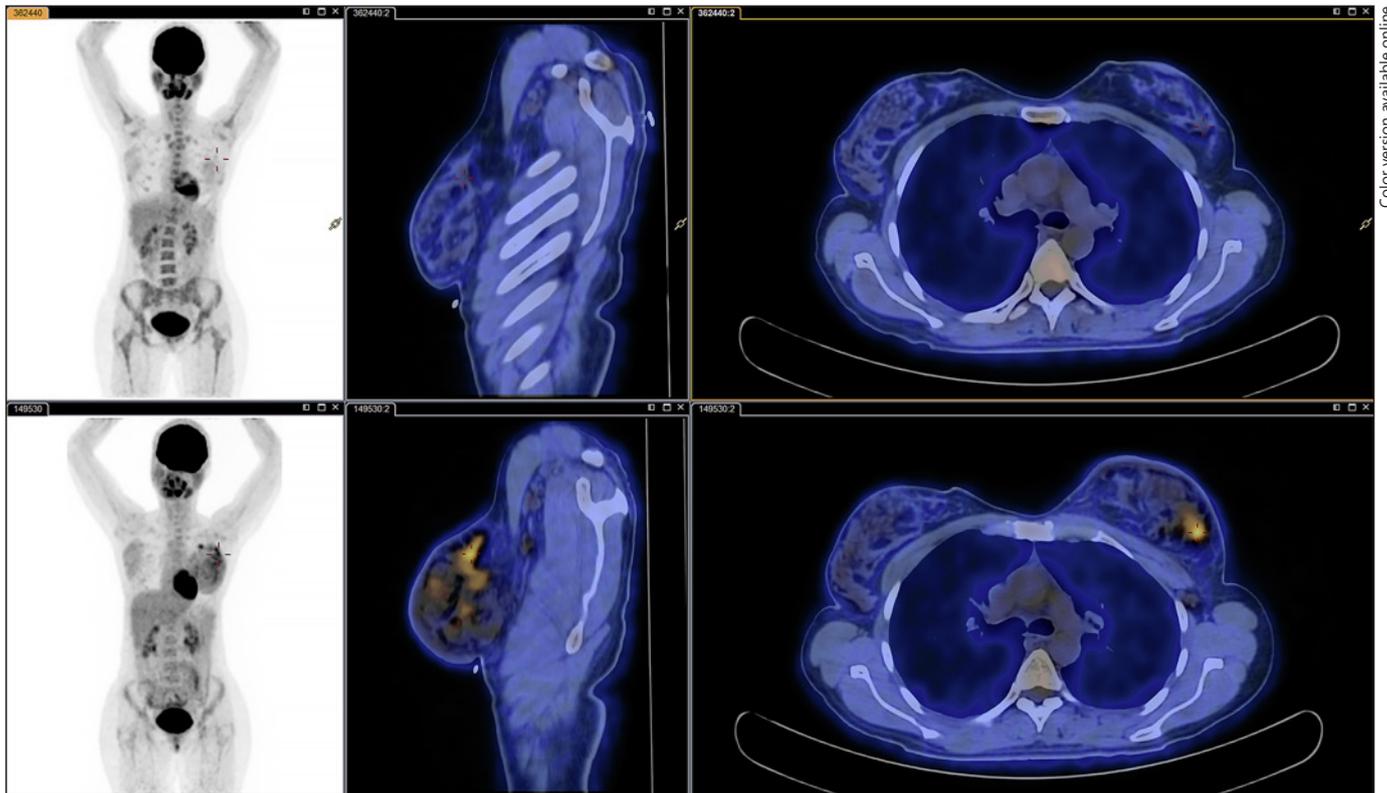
18F-FDG PET/CT images of a 41-year-old woman with locally advanced TN breast cancer. Before NAC (lower image), the images show a high uptake of FDG in breast tissue without any FDG uptake in axillary tissue. After the patient received a dose-dense chemotherapy regimen (upper image), the images show metabolic and anatomical regression by which after-surgery pCR was obtained.
